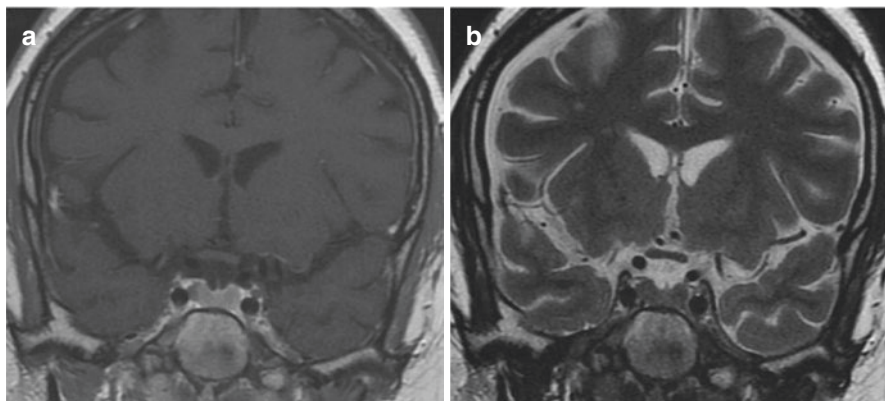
Pituitary magnetic resonance imaging coronal view in T1-weighted after gadolinium (a) and T2-weighted (b) sequences. A small 4 mm lesion with no contrast enhancement can be seen in the right side of the adenohypophysis in contact with left carotid artery. The lesion cannot be visualized in the T2 sequence
